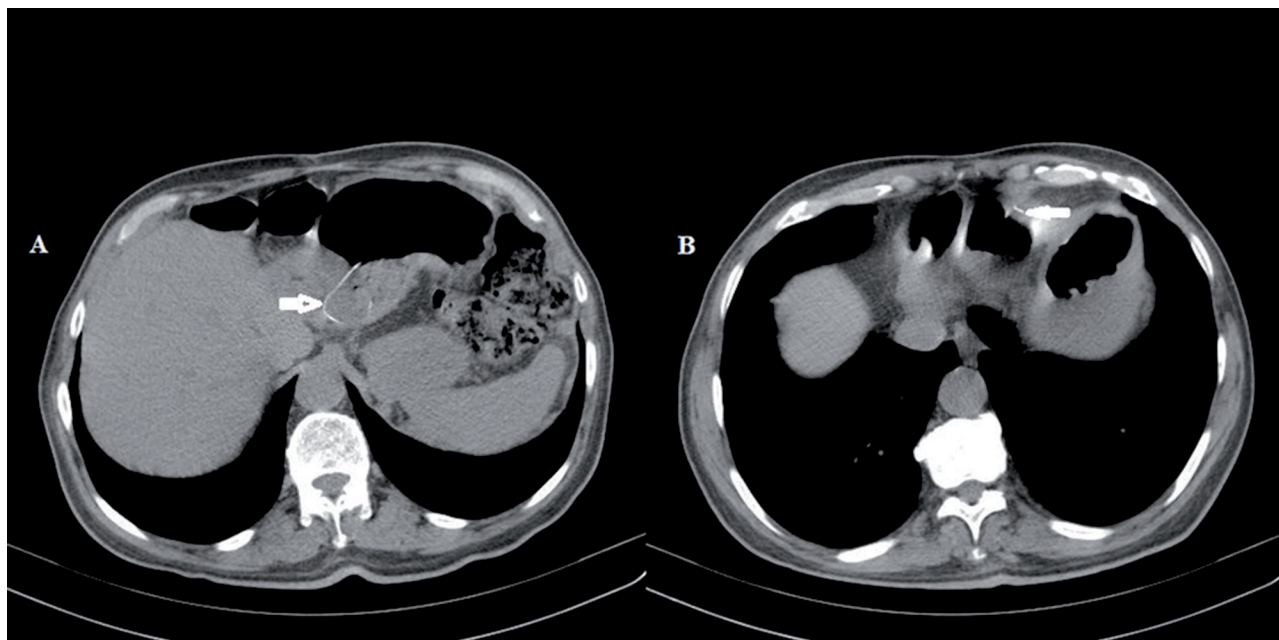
Computed tomography images showing a wire located at the right ventricle, passing through the sternocostal triangle, entering the abdomen, and penetrating the gastric wall (arrowhead).
